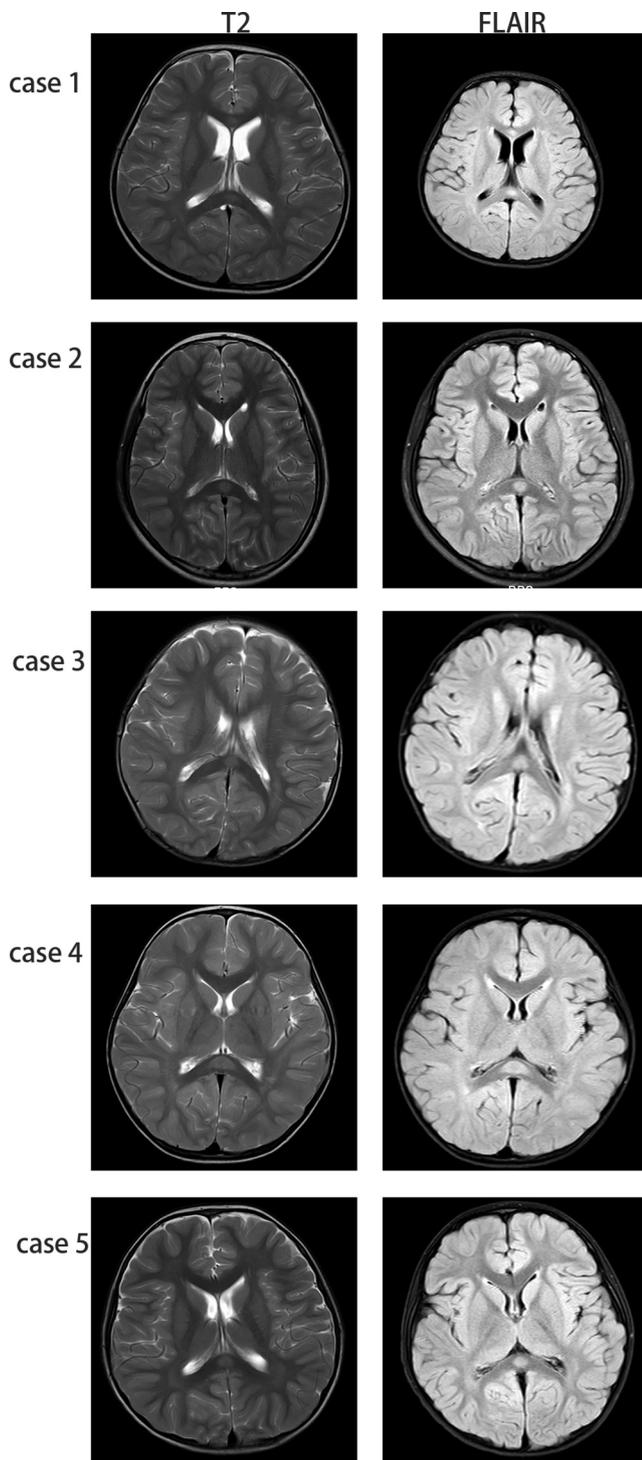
Axial T2-weighted images (T2) and FLAIR-weighted images (FLAIR) of the initial stage in all five cases. Case 1 showing focal lesions in the splenium of the corpus callosum and corpus callosum with hyperintense on T2 and FLAIR. The other 4 cases showing ovoid lesion in the splenium of the corpus callosum with hyperintense on T2 and FLAIR in the splenium of the corpus callosum.
